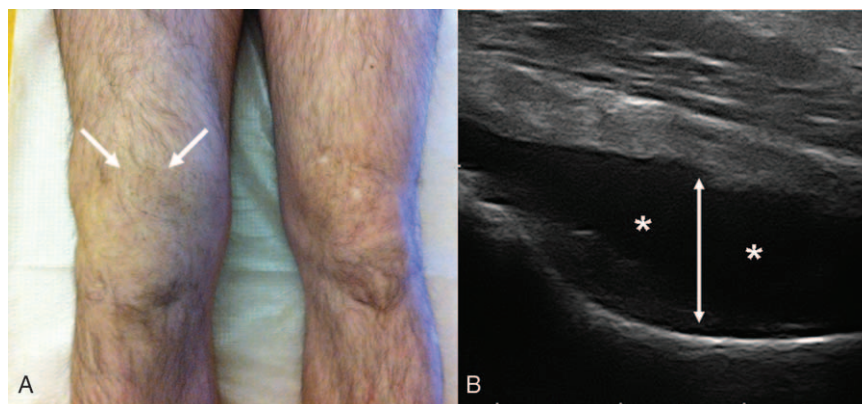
Joint inflammation related to meningococcal disease. (A) Joint effusion (white arrows) of the right knee in a patient with immune-mediated arthritis. (B) Ultrasonography of the hip. Presence of joint effusion (white asterisks) with joint capsule distension (white arrow) in a patient with primary septic meningococcal arthritis.
